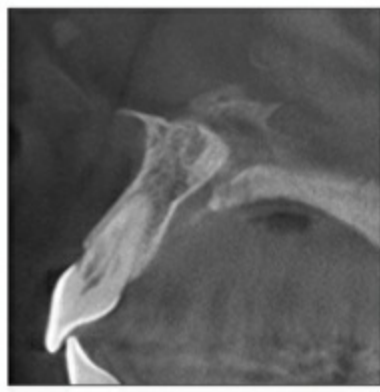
The 3D Accuitomo 80 CBCT (J Morita).
